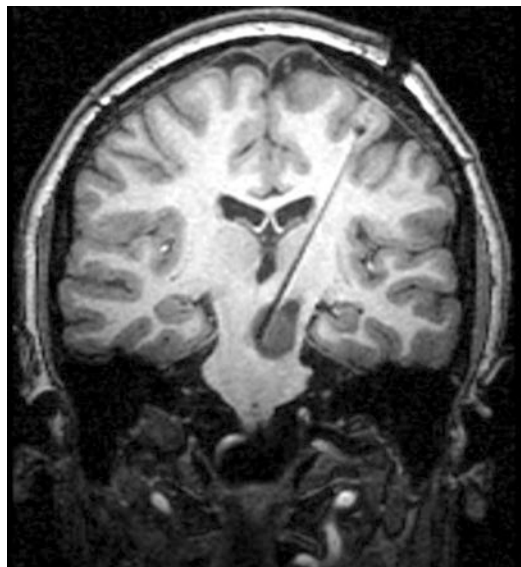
MRI acquired after the insertion of a laser fiber for LITT (laser interstitial thermal therapy)
